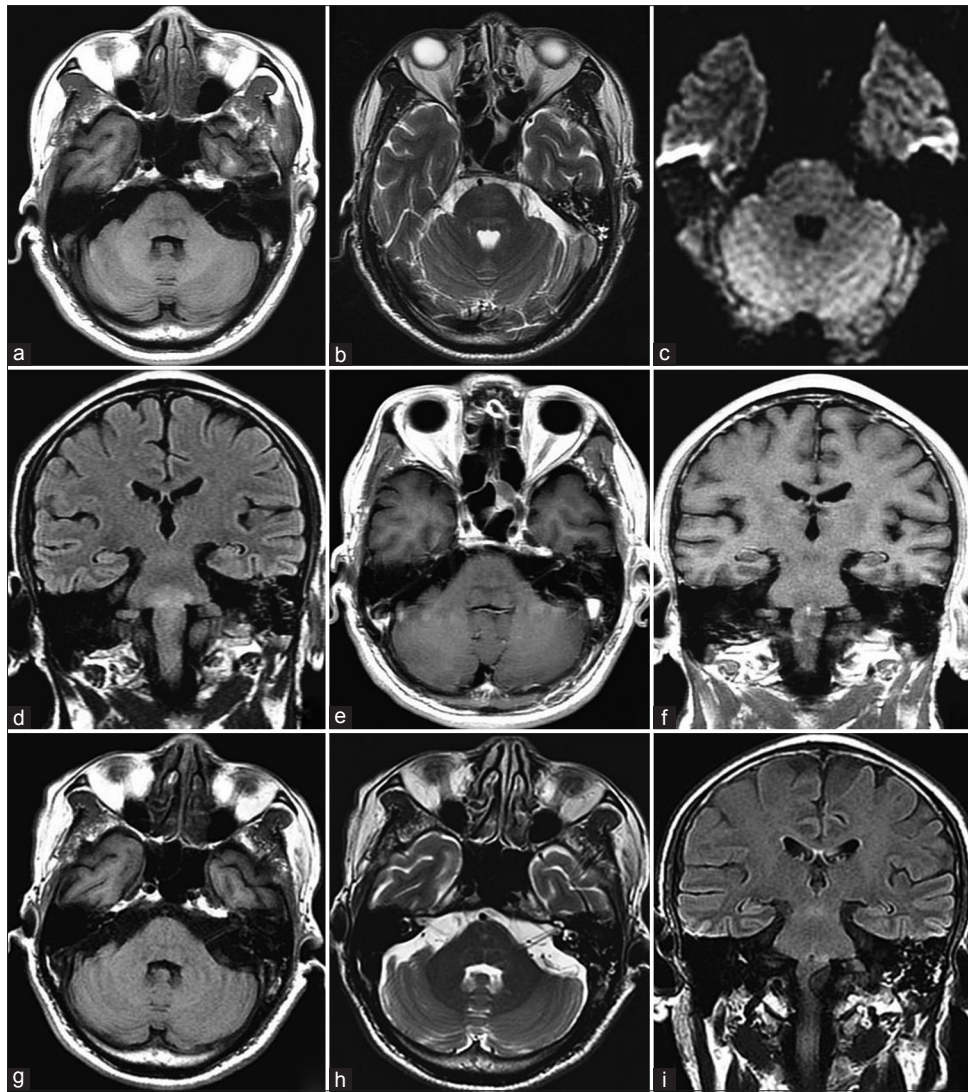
On admission, brain magnetic resonance imaging (MRI) shows the lesion in the basis pontis and medulla oblongata: T1-weighted hypointense (a), T2-weighted (b) and fluid attenuation inversion recovery (FLAIR) hyperintense (d), and slightly diffusion-weighted hyperintense (c). Contrast-enhanced T1-weighted MRI showed spot-like enhancement in medulla oblongata as well as enhanced left facial nerve (e and f). One month later, follow-up brain MRI demonstrates that the extent of the lesions has decreased on T1-weighted, T2-weighted images and FLAIR (g–i).
